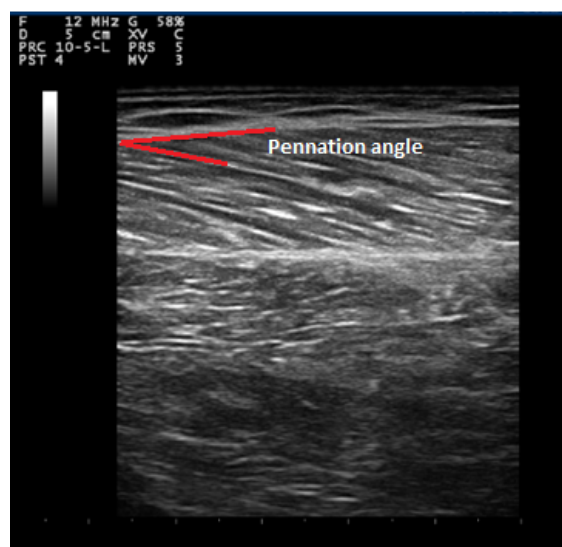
example ultrasound image
